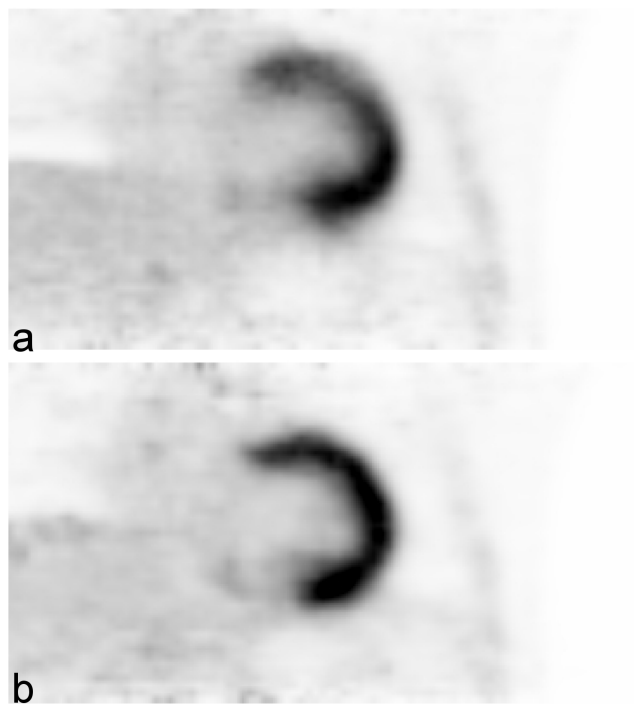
The image a) shows the ungated PET/CT images after attenuation correction. The image b) shows the same data after attenuation and motion correction. The blur and the apparently decreased tracer uptake of the anterior wall on image a) is corrected to a great extent in image b).
